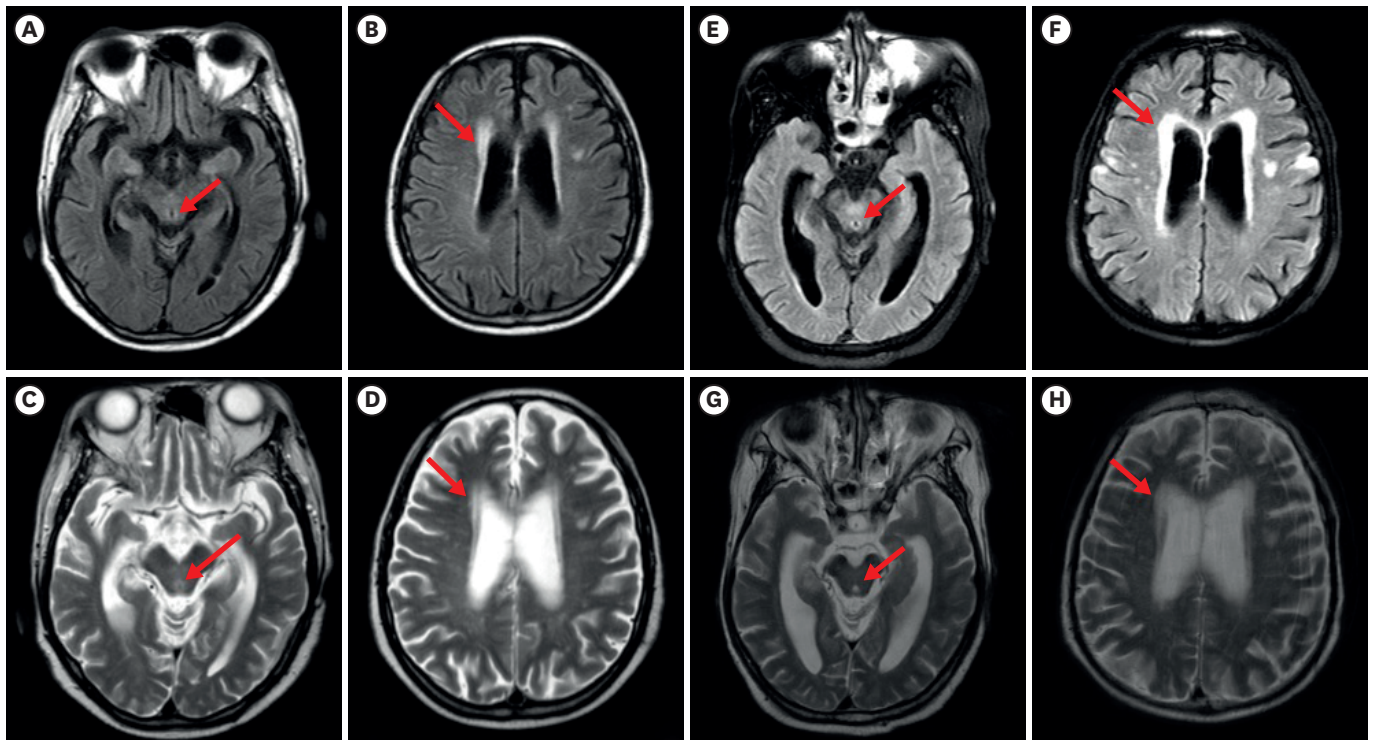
Axial images of brain MRI when WE was diagnosed 3 years ago (left) and MBD was diagnosed at current admission (right). MRI showed hyperintensities in FLAIR (A, B, E, and F) & T2WI (C, D, G, and H) in the bilateral periaqueductal area and periventricular area (arrow in A-H). MRI, magnetic resonance; WE, Wernicke encephalopathy; MBD, Marchiafava-Bignami disease; AP, alcoholic polyneuropathy; FLAIR, fluid attenuated inversion recovery; T2WI, T2-weighted image.
